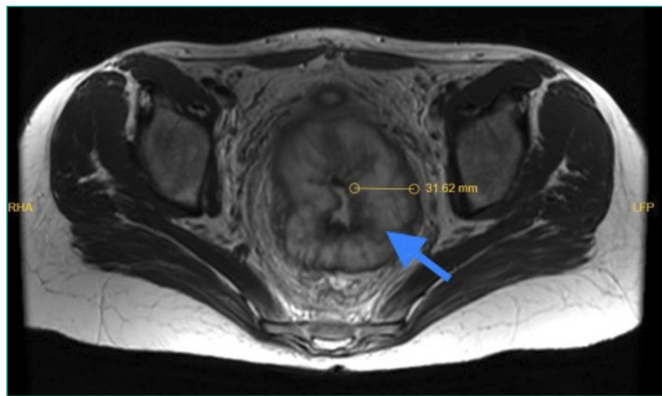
Irregular wall thickening in the rectum in pelvic MRI (blue arrow)
